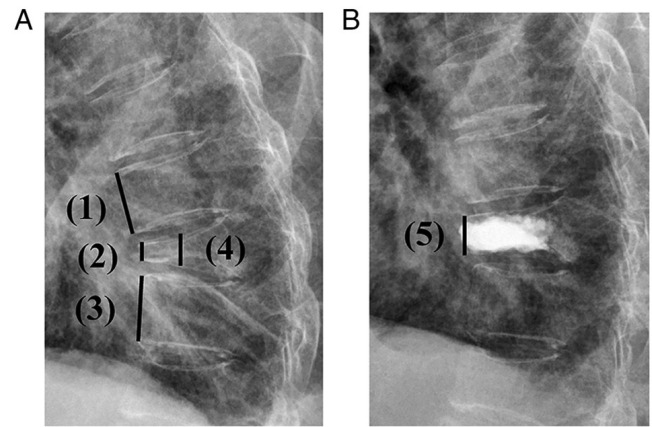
Compression and restoration rates. (A) Preoperative X-ray at lateral view. (B) Postoperative 1-day X-ray at lateral view. Radiographic evaluation of anterior (2) and middle (4) vertebral body height, neighbouring normal vertebral body height [(1) and (3)]. Radiographic evaluation of fractured vertebral body height (2) and restored vertebral body height (5). Compression rate =  $(2)/[(2)+(3)]/2 \times 100\%$ . Restoration rate =  $[(5)-(2)]/[(1)+(3)]/2 \times 100\%$ .
